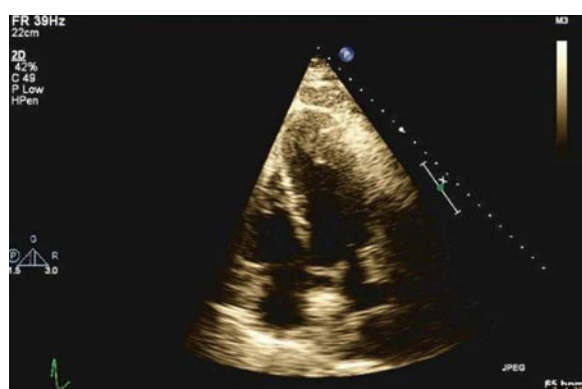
A 2D transthoracic echocardiogram showing left ventricular apical hypertrophy.
